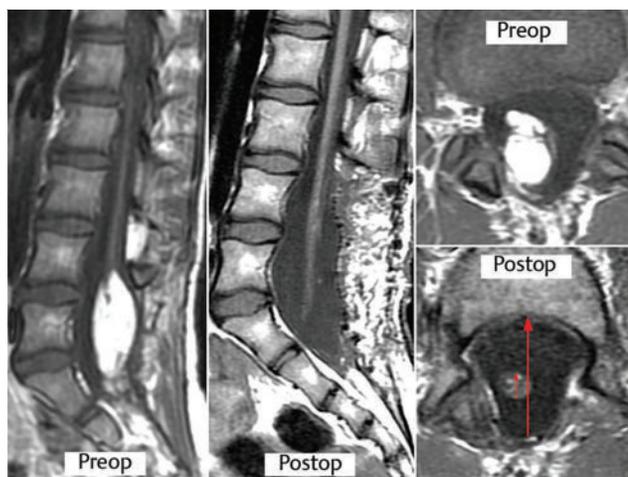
The pre- and postoperative sagittal and axial magnetic resonance images of a 10-year-old girl who had undergone two previous partial resections of a large transitional lipoma and who was also highly symptomatic. The achieved postoperative cord–sac ratio was 20% (lower right), and she enjoyed long-term progression-free status.
